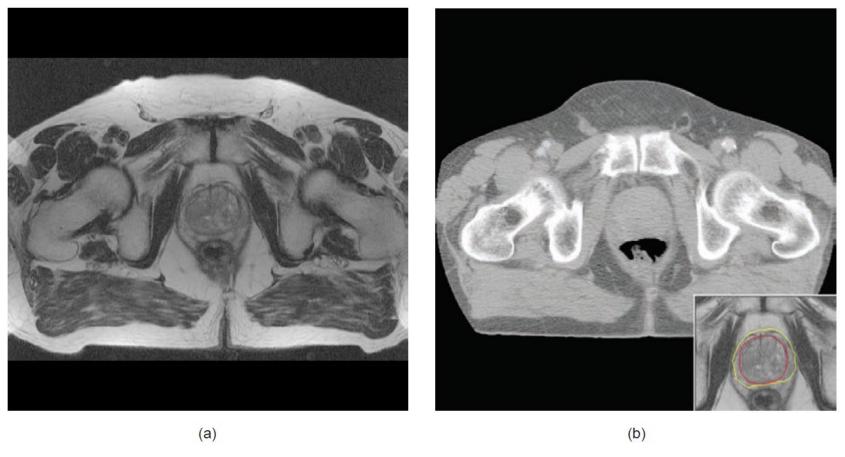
(a) MR image obtained with a T₂-weighted TurboSE sequence (TE = 120 ms, TR = 6 s) through the prostate. (b) CT image of the same cross-section. The images of both modalities were geometrically registered with image fusion software. The contour of the prostate was manually outlined in both images (see lower right corner; MRI red contour, CT yellow contour). CT systematically overestimates the prostate volume because of the low contrast between prostate tissue and adjacent periprostatic structures, which can only be differentiated in the MR image.
